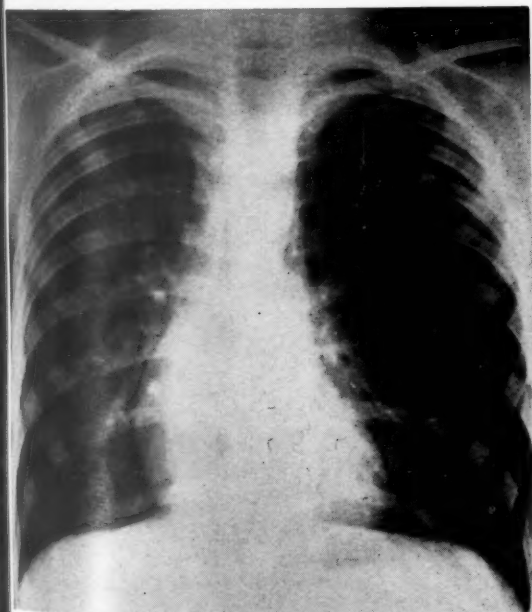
Case 1. Chest radiograph February 4, 1955, showing some emphysema still and a slight degree of mediastinal shift.
